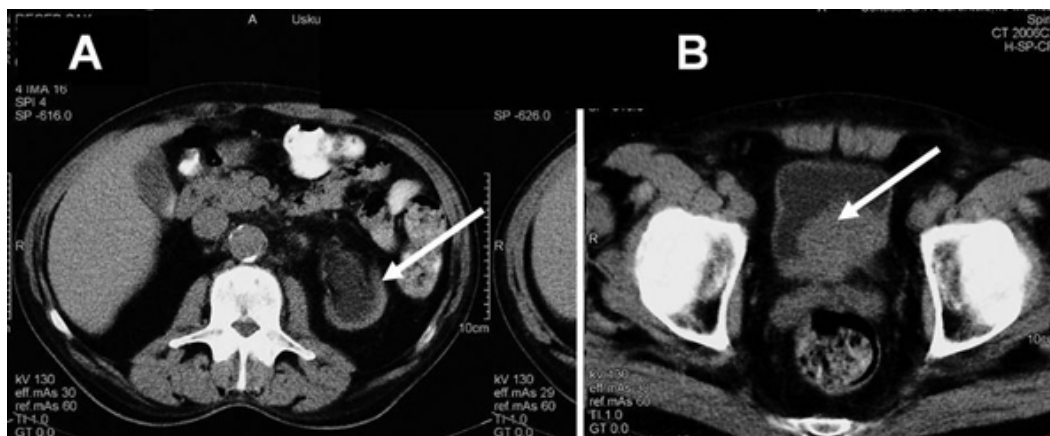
Figure I A-B: CT scan of kidney and bladder
